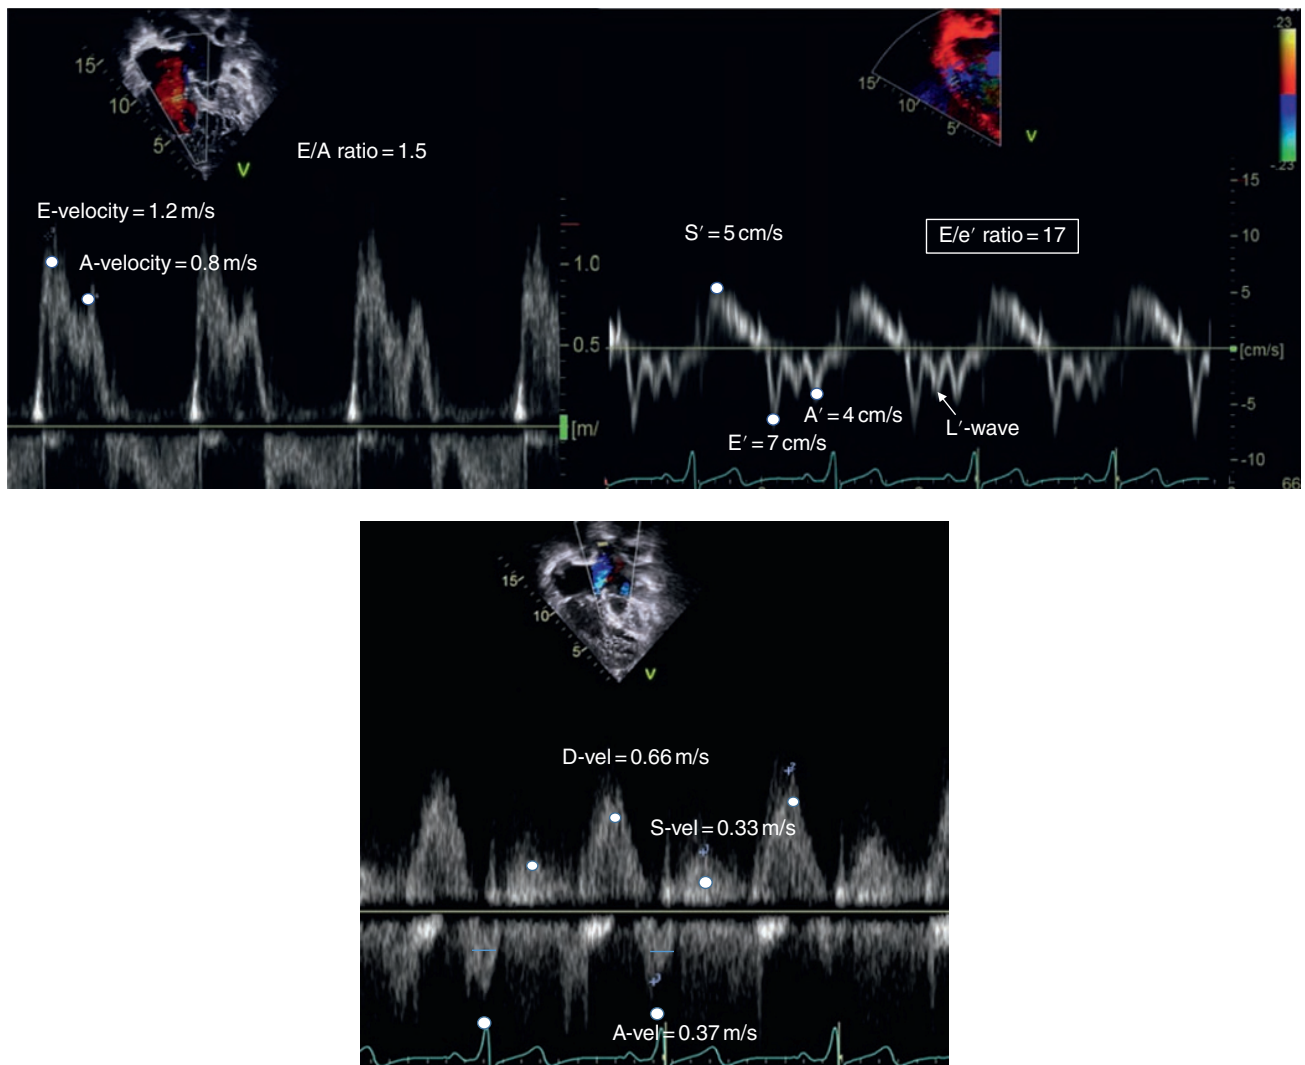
Diastolic function assessment in a patient with hypoplastic left heart syndrome after Fontan. The tricuspid inflow has increased E-velocity and high A-velocity with normal E/A ratio. The tissue Doppler tracing demonstrates low tissue Doppler velocities in the lateral tricuspid annulus. This is a common finding in postoperative patients. E'-velocity is higher than A'-velocity with mid-diastolic motion (L'-wave). This possibly suggests some delay in right ventricle (RV) relaxation with mid-diastolic motion. The E/E' ratio is high but is not very useful in postoperative patients as E'-velocities are often reduced, possibly because of tethering of the RV base related to adhesions. The pulmonary vein tracing demonstrates high diastolic flow and somewhat reduced systolic flow with prominent A-wave reversals. This demonstrates that interpretation of the conventional diastolic parameters is extremely difficult in Fontan patients. The normal S/D ratio in this patient suggested normal filling pressure.
